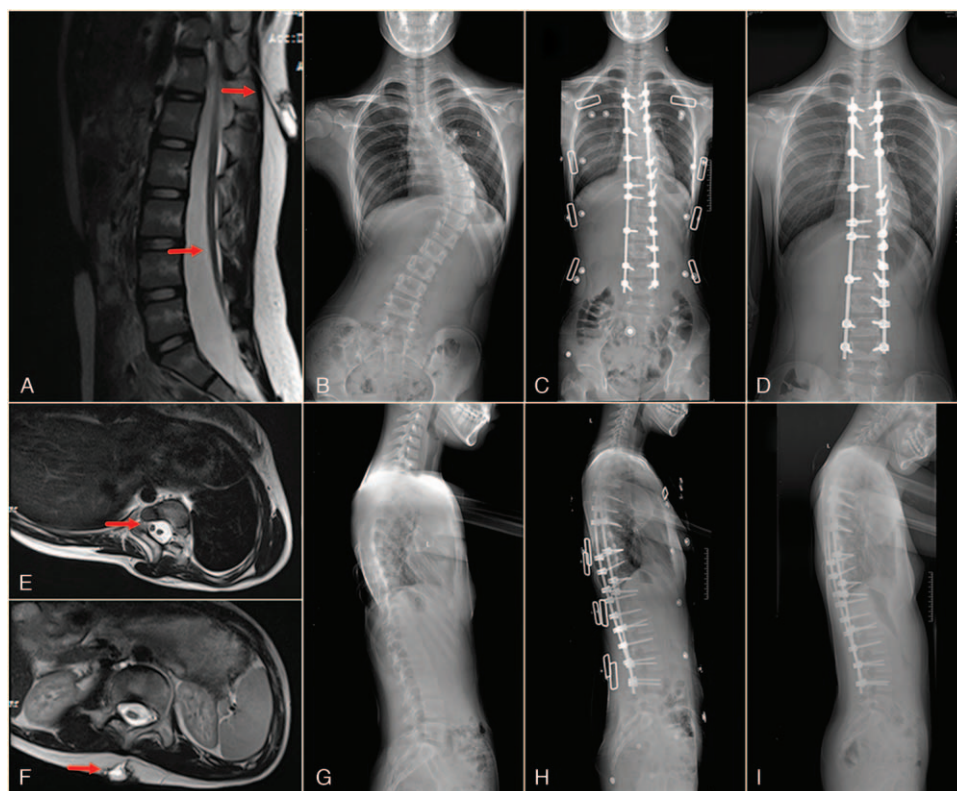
A 13-year-old girl with congenital scoliosis and 3 intraspinal anomalies (coexisting tethered cord, myelomeningocele and type 2 split cord malformation [SCM]) received posterior correction and instrumentation without preliminary neurosurgical intervention. No neurologic deficits were found before or after surgery. (A) Tethered cord and myelomeningocele on sagittal magnetic resonance imaging. (E,F) Type 2 SCM and myelomeningocele on axial magnetic resonance imaging. Preoperative anteroposterior (B) and lateral (G) views. Postoperative anteroposterior (C) and lateral (H) views. Final follow-up anteroposterior (D) and lateral (I) views.
